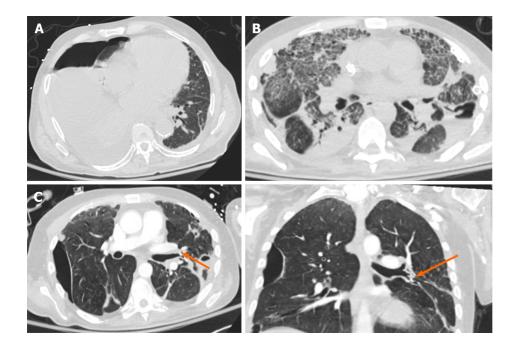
Computed tomography chest in axial view. A: Computed tomography (CT) chest in axial view showing presence of hydropneumothorax needing the placement of a 14F chest tube; B: CT chest in axial view of a 45-year-old patient showing pneumothorax with chest tube in left side (arrow); C: With a persistent air leak, endobronchial valves were placed in the lingula as seen on axial and coronal views (arrow).
